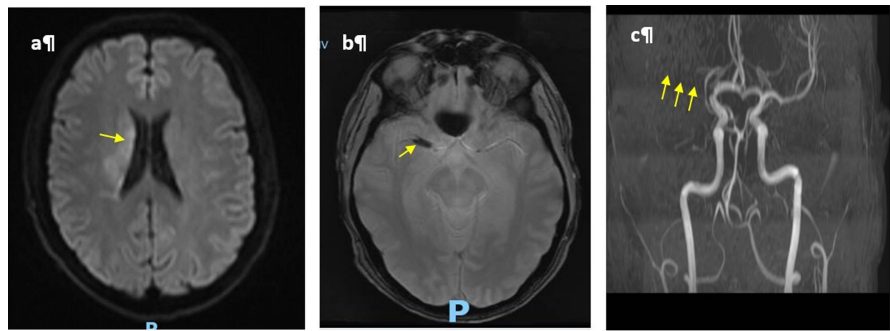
MRI performed 2 hr. 20 min after symptom onset shows acute ischemic lesions in the deep region of the right MCA on diffusion weighting (a); T2*-weighted sequences show M1 thrombus on the right, and angiographic sequences show occlusion of the right MCA (c).
